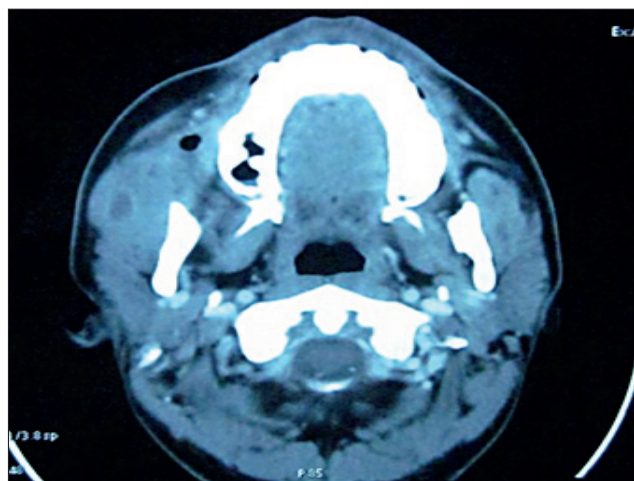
3D CT scan showing an abscess within the right masseter muscle and inflammatory changes in the surrounding masticator space
